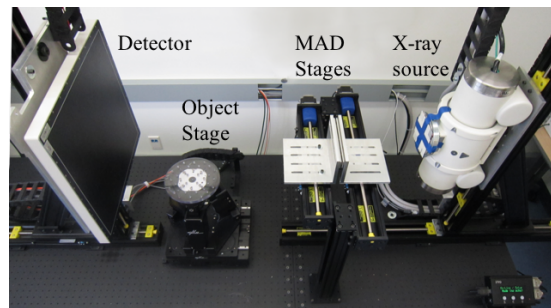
CBCT Test Bench
